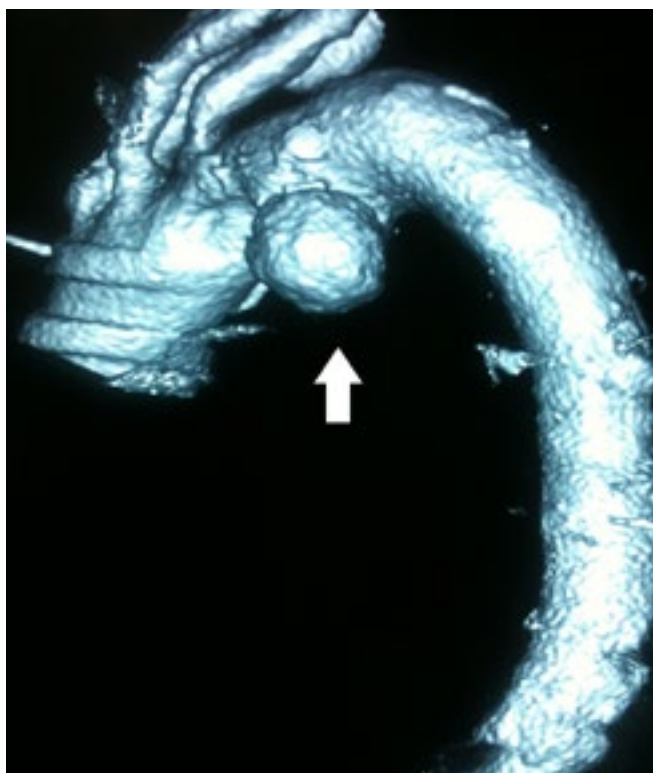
CT angiogram revealed saccular thoracic aneurysm (arrow). The left RLN usually passes at this area which is below and behind the aorta at the level of the ligamentum arteriosum.
